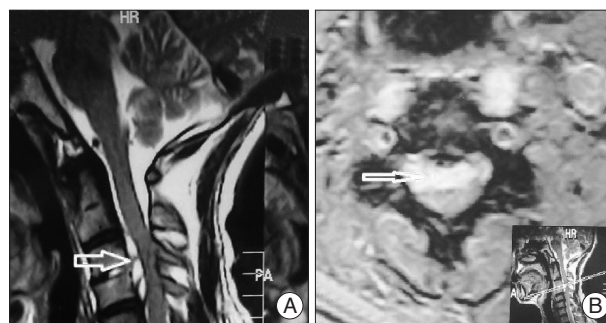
A : Sagittal T2 weighted magnetic resonance imaging (MRI) of Case 2 revealing hyperintense lesion and spinal cord compression due to epidural abscess at C3-4 level (arrow). B : Axial T2 weighted MRI of Case 2 reveals hyperintense lesion and spinal cord compression due to epidural abscess (arrow).
